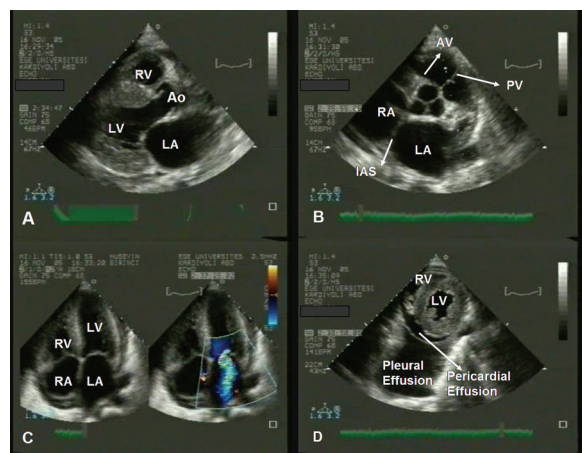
Parasternal long- and short-axis views (A, B, D) and apical 4-chamber (C) view show concentric left ventricular hypertrophy, thickening of the interatrial septum, myocardial granular sparkling texture, patent foramen ovale, mitral regurgitation, and pleural and pericardial effusion. RV indicates right ventricle; LV, left ventricle; RA, right atrium; LA, left atrium; Ao, aorta; IAS, interatrial septum; AV, aortic valve; PV, pulmonary valve.
